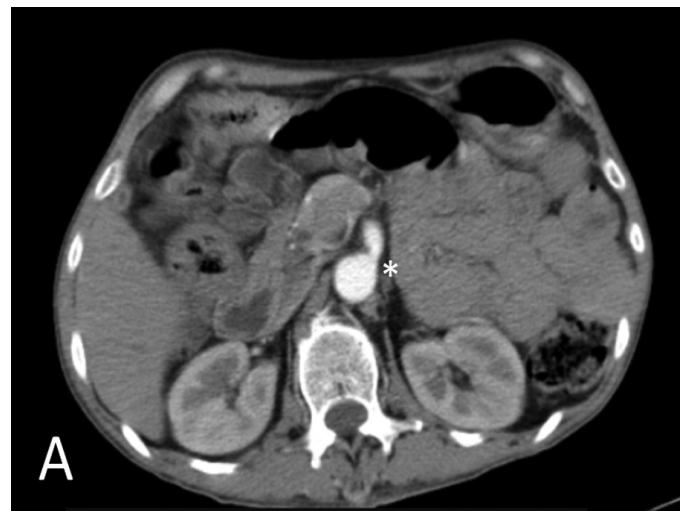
A. Narrowing of the superior mesenteric artery (asterisk) on CT imaging; B. Narrowing of superior mesenteric artery (arrow) demonstrated on 3D reconstructed angiographic CT images.
